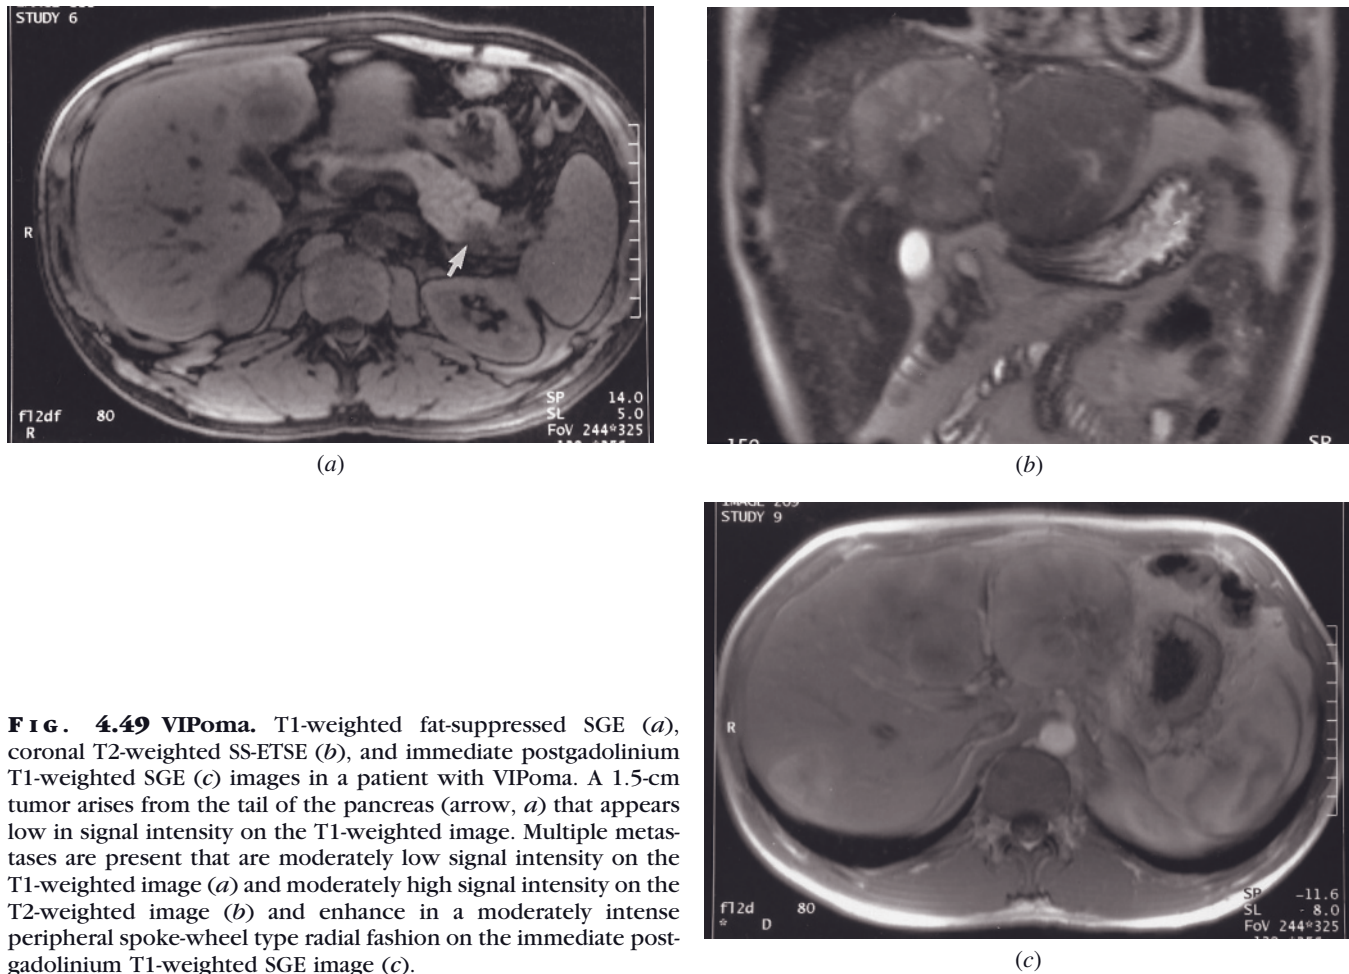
VIPoma. T1-weighted fat-suppressed SGE (*a*), coronal T2-weighted SS-ETSE (*b*), and immediate postgadolinium T1-weighted SGE (*c*) images in a patient with VIPoma. A 1.5-cm tumor arises from the tail of the pancreas (arrow, *a*) that appears low in signal intensity on the T1-weighted image. Multiple metastases are present that are moderately low signal intensity on the T1-weighted image (*a*) and moderately high signal intensity on the T2-weighted image (*b*) and enhance in a moderately intense peripheral spoke-wheel type radial fashion on the immediate postgadolinium T1-weighted SGE image (*c*).
